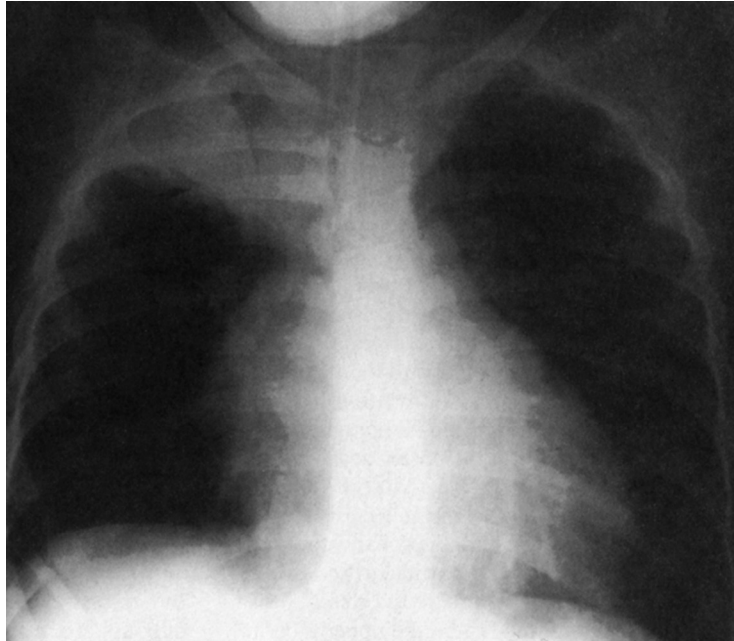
Anteroposterior chest radiograph with right upper lobe atelectasis.
